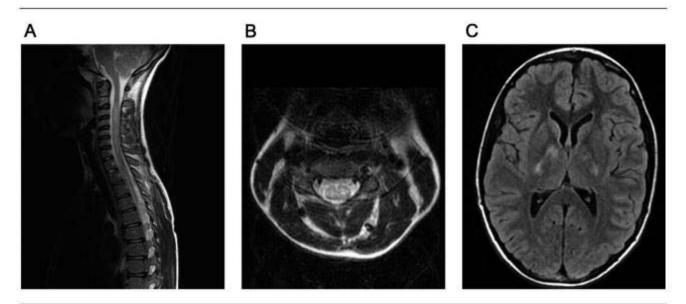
A 14-year-old boy with acute disseminated encephalomyelitis with spinal cord involvement. A, Sagittal T2 image of the spine showing T2 hyperintensity in the cervical region with cord expansion. B, Axial T2 image with holocord pattern of hyperintensity. C, Axial FLAIR image of the brain showing basal ganglia hyperintensity. FLAIR = fluid-attenuated inversion recovery.
